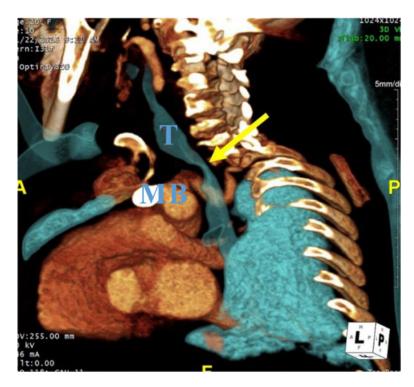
CT angiography (CTA) of a 20-year-old woman with MPS IVA. 3D oblique reconstruction of CTA demonstrates marked narrowing of the trachea at the thoracic inlet (yellow arrow). T– Trachea, B- Brachiocephalic artery, M- Manubrium.
